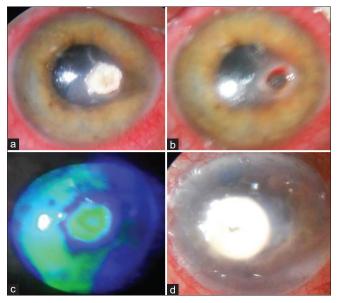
Complications of ICSP CTA technique. (a) Sealed corneal perforation 6 weeks post ICSP CTA application. (b) Inadvertent extrusion of scleral patch at the time of removal of CTA. (c) Negative Seidel's test, treated with BCL. (d) Cosmesisissue in patientwith healed corneal perforation (4.5 mm) at 18 weeks follow-up
